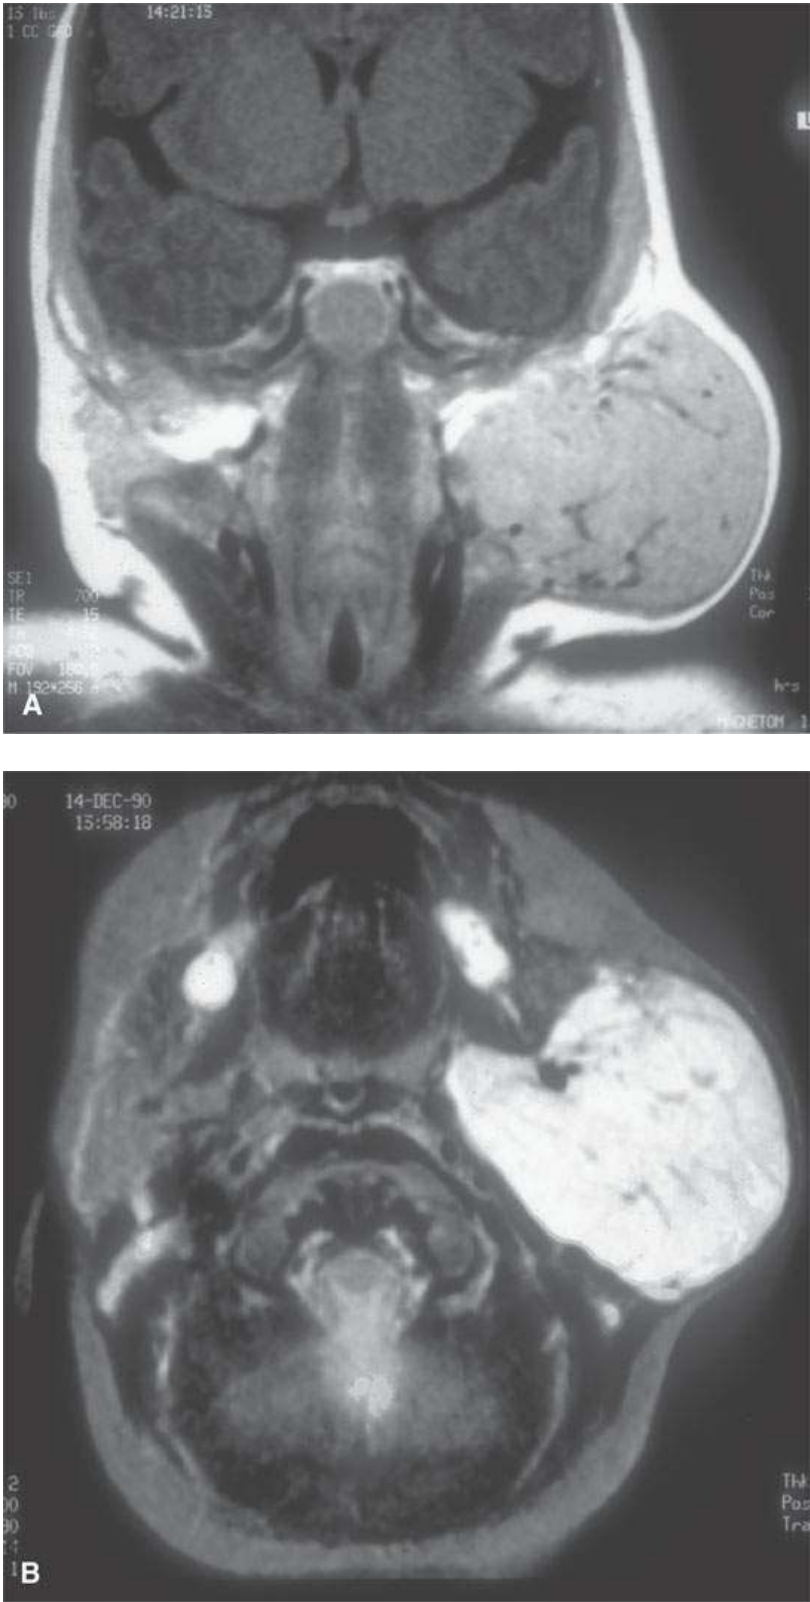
Magnetic resonance imaging of a parotid proliferative hemangioma, with the contrast-enhanced T1-weighted image in (A) reflecting the blood pool nature of its many tiny cystic spaces filled with relatively static blood and the T2-weighted image in (B) showing the intensely bright signal again reflecting the basically microcystic nature of the mass.
